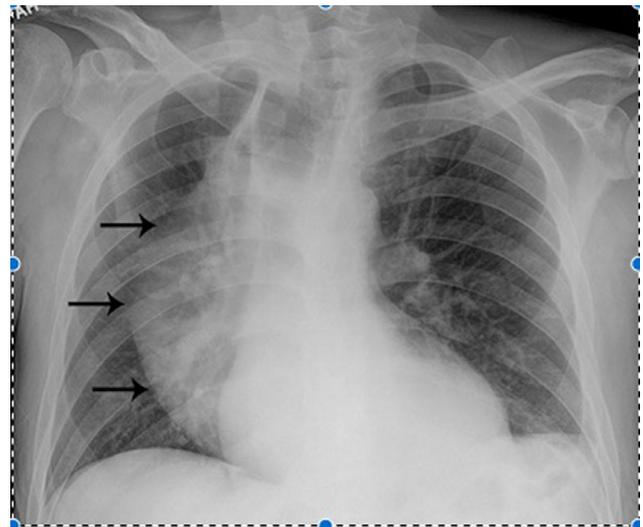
Posteroanterior radiograph of the chest x-ray shows a widened mediastinum, with a well-defined opacity extending to the right hemithorax (arrows), suggestive of a dilated esophagus.
